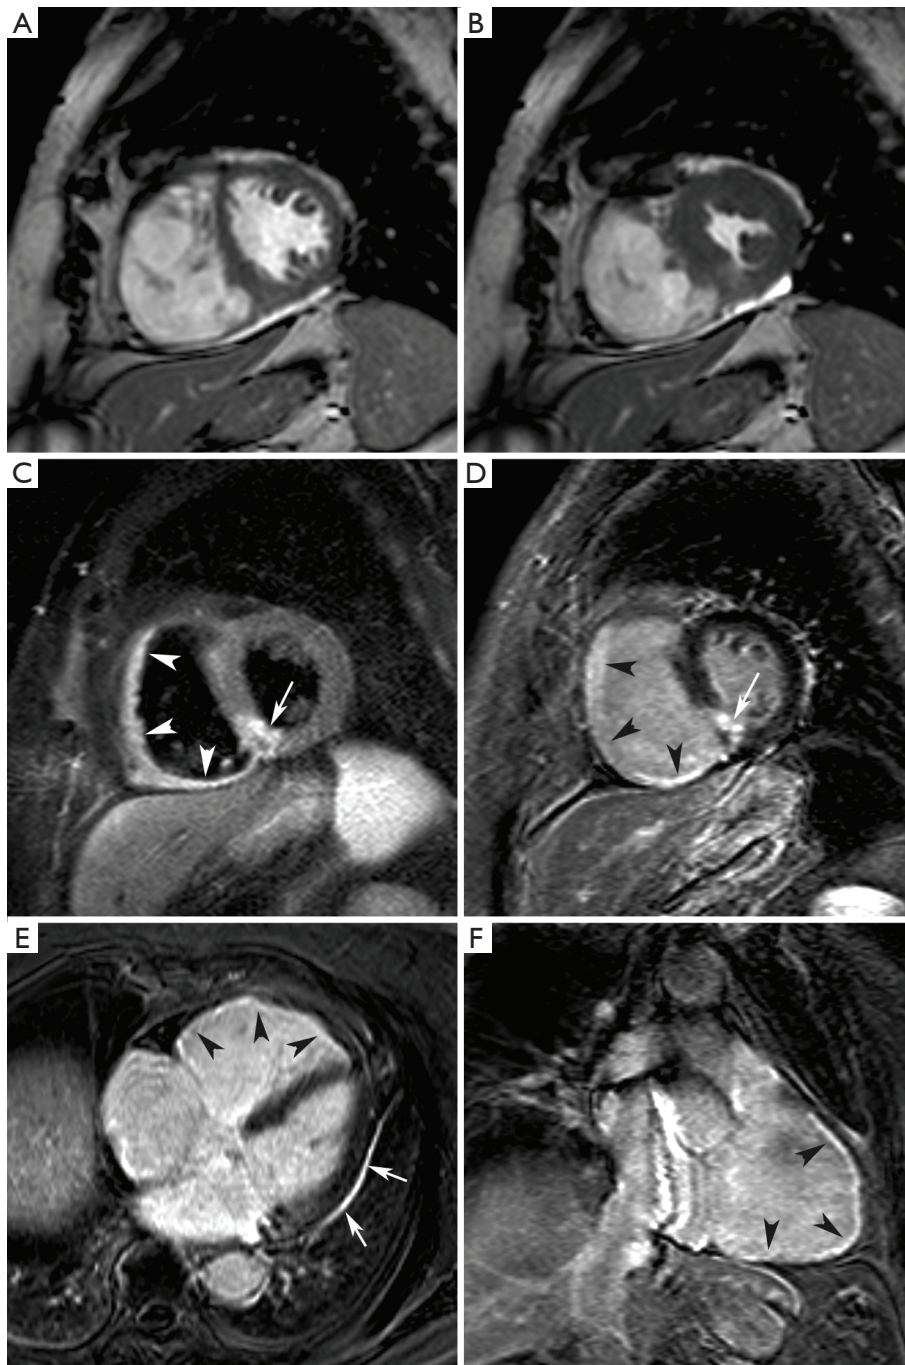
Nearly isolated RV infarction in 82-year-old woman. Short-axis cine at end diastole (A) and end systole (B), short-axis T2 weighted STIR imaging (C). Late gadolinium imaging in short-axis (D), horizontal long-axis (E) and RV vertical long-axis (F). Moderately dilated and dysfunctional RV (EDV: 197 mL, EF: 39%) and nearly normal LV volumes and function (EDV: 109 mL, EF: 63%). Diffuse RV myocardial edema (*arrowheads*, C) with limited edema in inferoseptal LV wall (*arrow*, C). Late gadolinium imaging shows diffuse RV myocardial enhancement (*arrowheads*, D,E,F). Focal transmural enhancement in inferoseptal LV wall (*arrow*, D). Note the presence of some pericardial enhancement along the lateral LV border (*arrows*, E). Adapted from Ischemic Heart Disease by Bogaert J and Dymarkowski S, in *Clinical Cardiac MRI Second Edition*, Bogaert J, Dymarkowski S, Taylor AM, Muthurangu V (eds). Springer Heidelberg, Germany (ISBN 978-3-642-23034-9)
